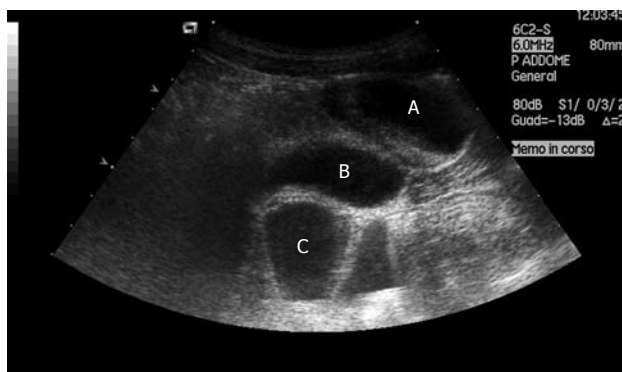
Abdominal ultrasound: anechoic oval supraventricular lesion with fluid-fluid level (A); bladder (B); bowel (C).
